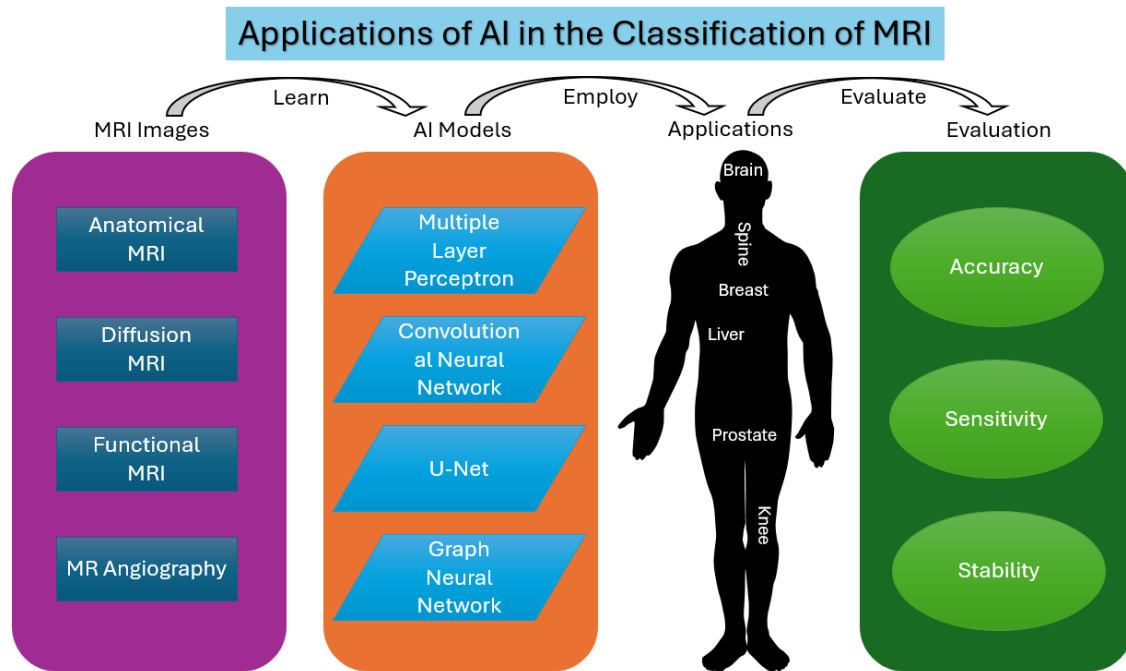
First review MRI images and select the previously labeled dataset by an expert. Next, select AI models applied to learn those MRI images. Then, applied those to MRI applications that employ AI models. Finally, discuss the evaluation metrics proposed to evaluate these AI models’ performance.
